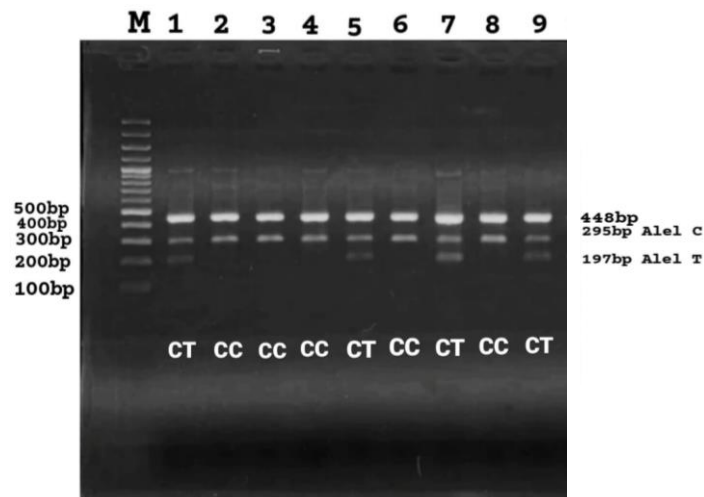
ARMS-PCR results of Angiotensinogen rs699. The CC genotype was marked by the appearance of the C allele and main band in 295 bp and 448 bp DNA fragments. The CT genotype was characterized by the C and T alleles in 295 bp and 197 bp fragments and the main band in the form of 448 bp DNA fragments. M as a marker.
